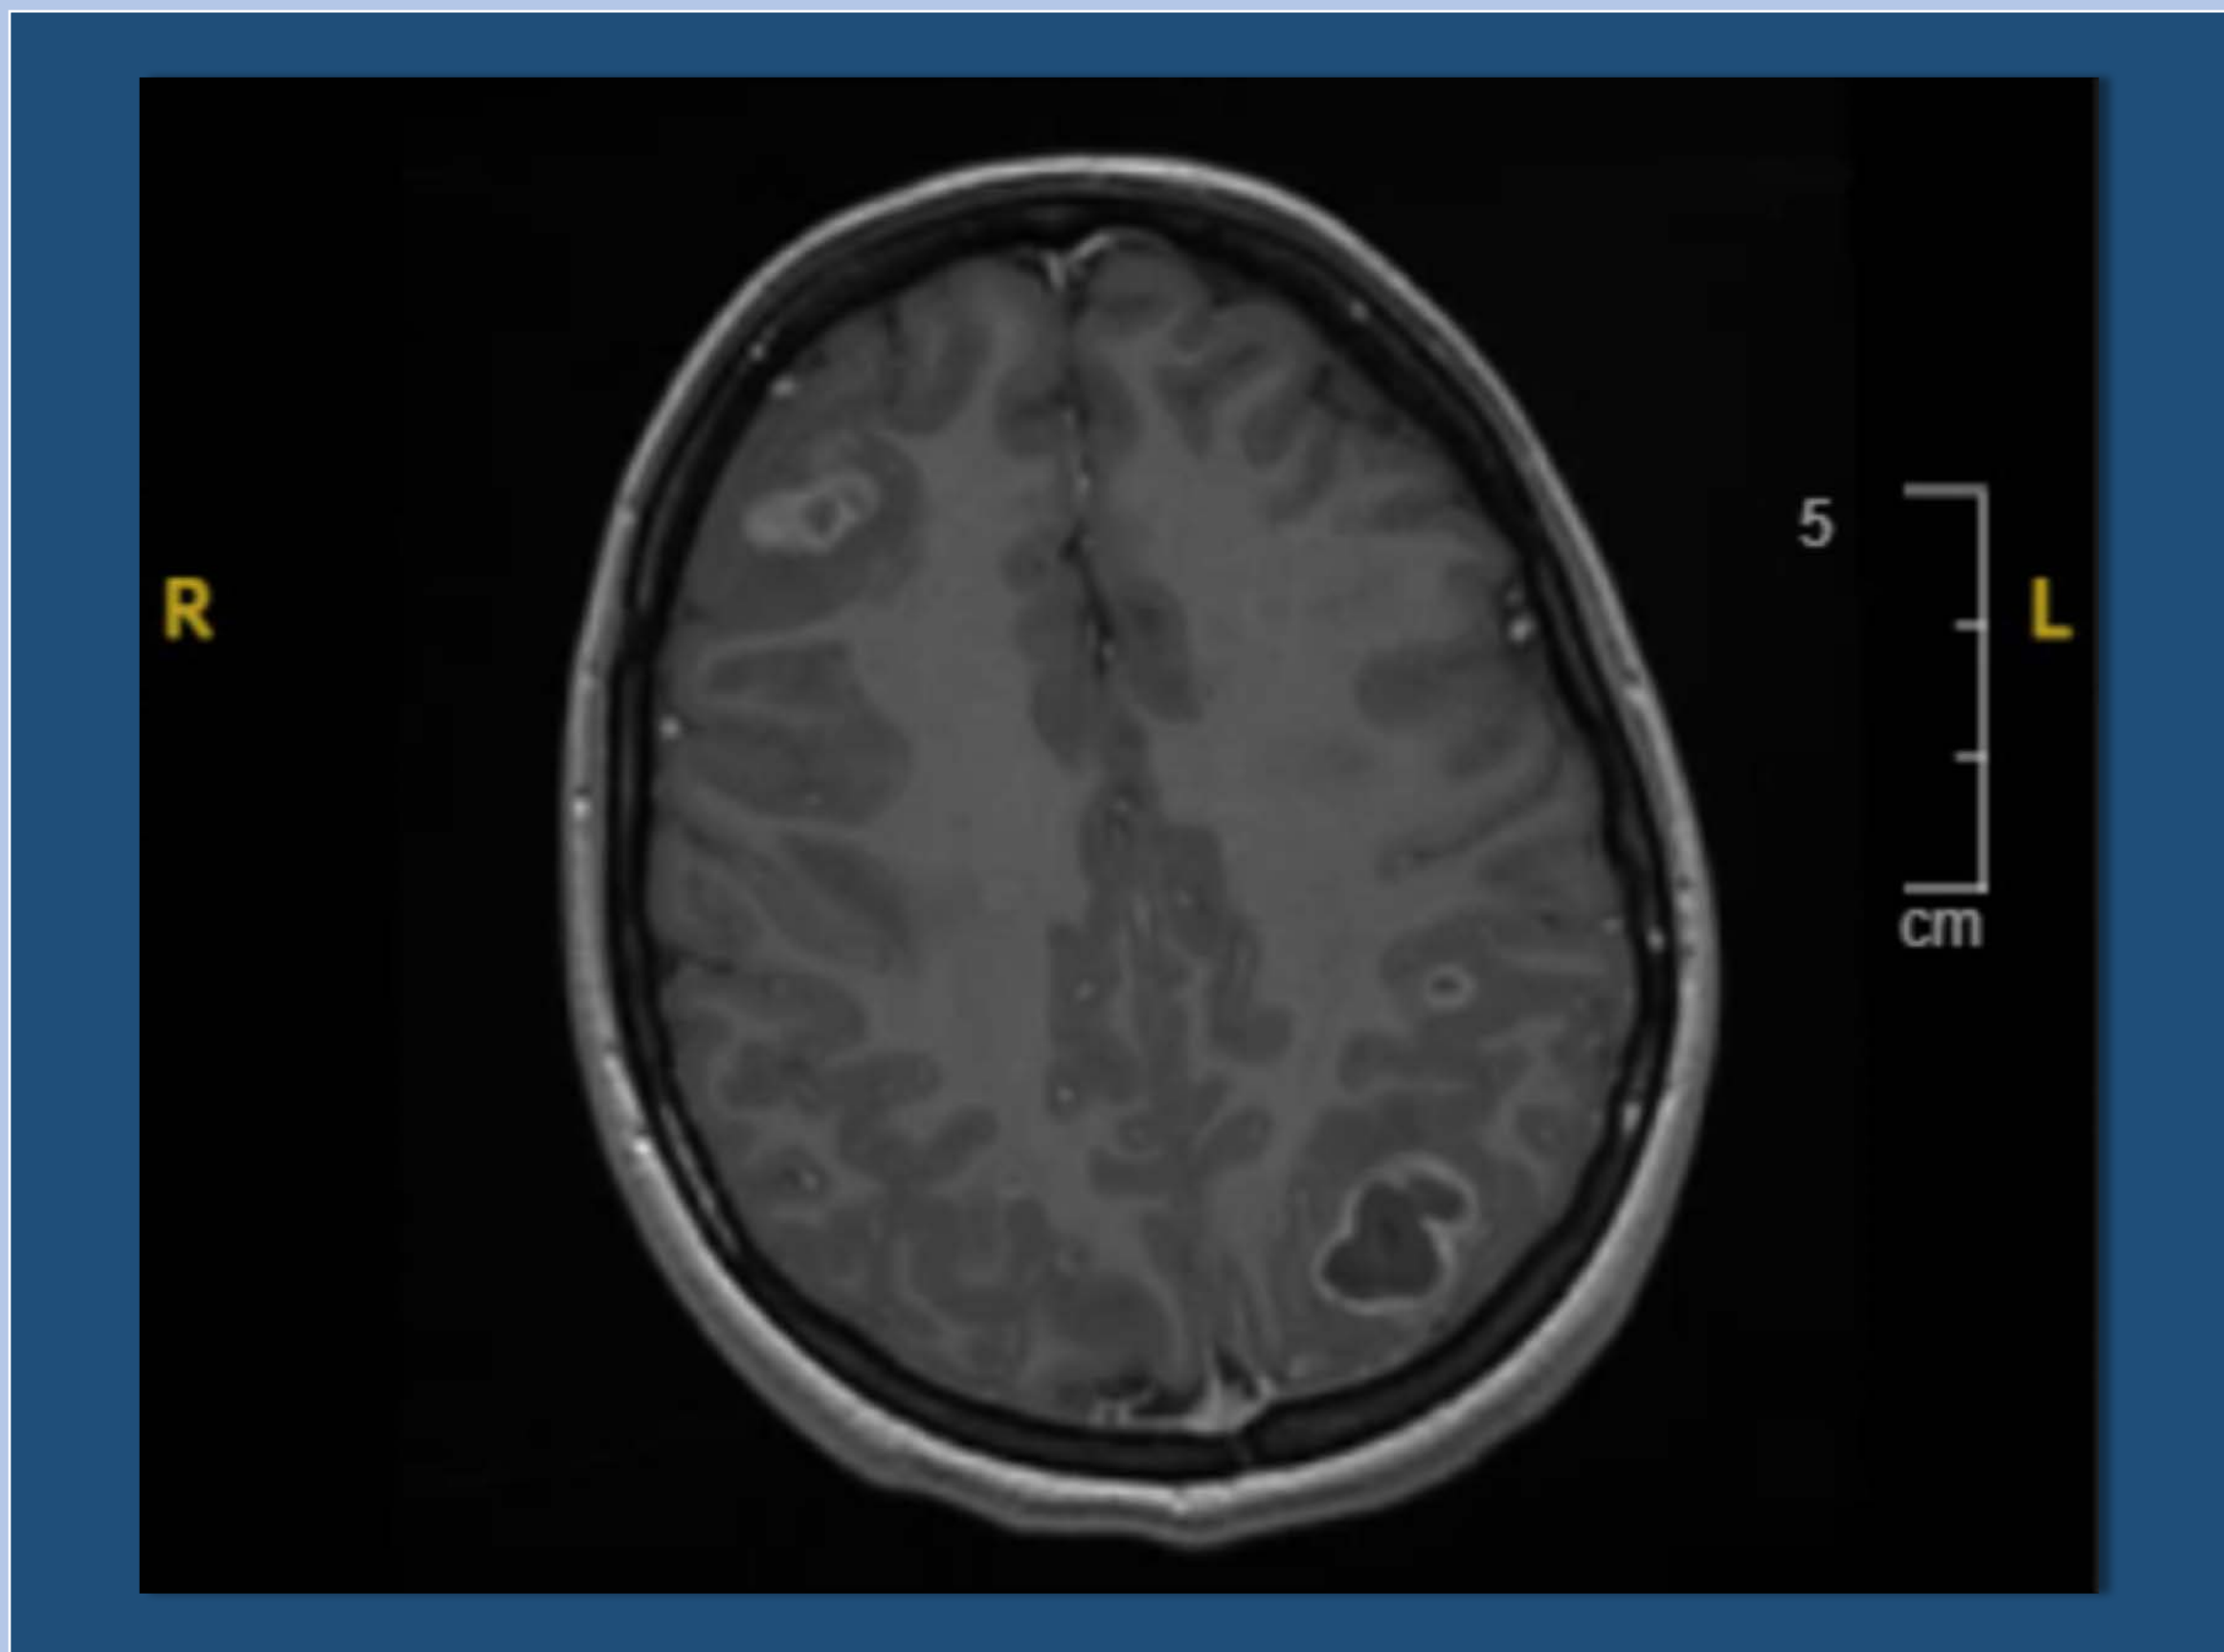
MRI After Initiation of Steroids and IVIG
